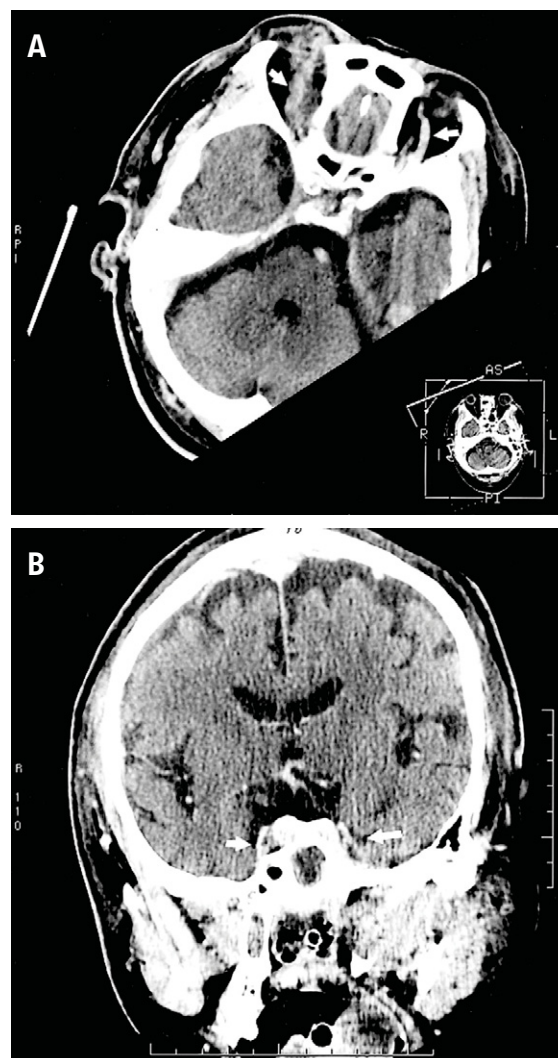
Case 8: (A) contrast-enhanced computed tomography (CT) with thin section (3-mm thick section) and three-dimensional reconstruction in the axial view reveals indirect signs of cavernous sinus thrombosis, including bilateral enlarged superior ophthalmic veins (arrows) and soft tissue in the right retrobulbar region, but does not show direct signs of abnormal cavernous sinuses; (B) coronal contrast-enhanced CT with thin section (3-mm thick section) reveals filling defects and bulges at bilateral cavernous sinuses (arrows).
